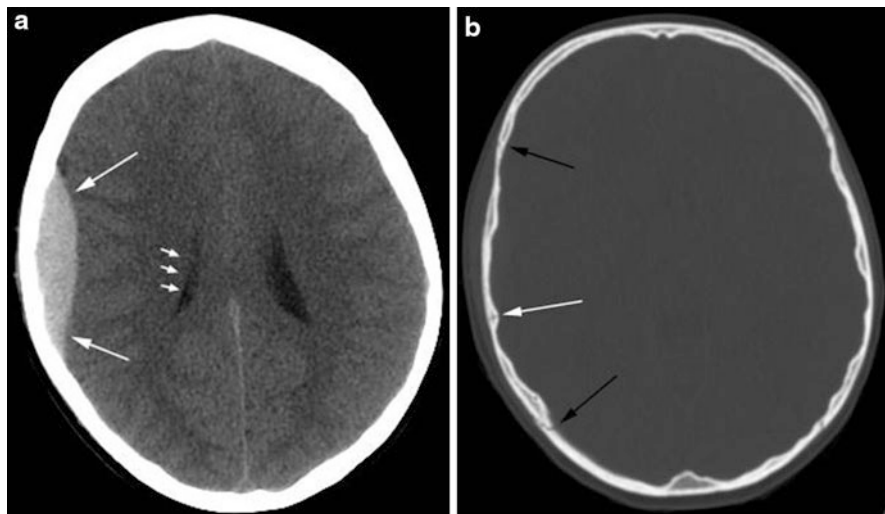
EDH. 11-year-old fall from the top bunk of a bunk bed. An axial noncontrast CT image (a) shows an acute epidural hematoma (*large white arrows*) which has mass effect on the adjacent right frontal and parietal lobes with partial effacement of the right lateral ventricle (*small white arrows*). The corresponding CT image in bone windows (b) shows a fracture of the right parietal bone (*white arrow*). Notice how the epidural hematoma is limited by the coronal and lambdoid sutures indicated by the *black arrows*
